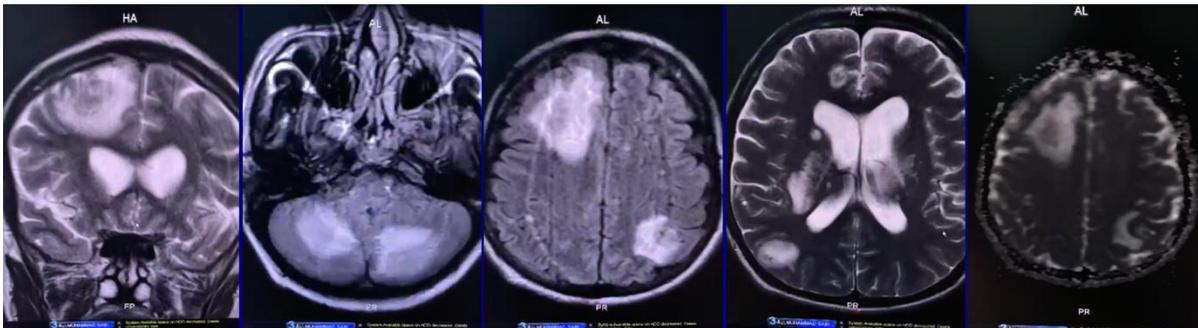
MRI Brain reveals multiple lesion in cerebral.
